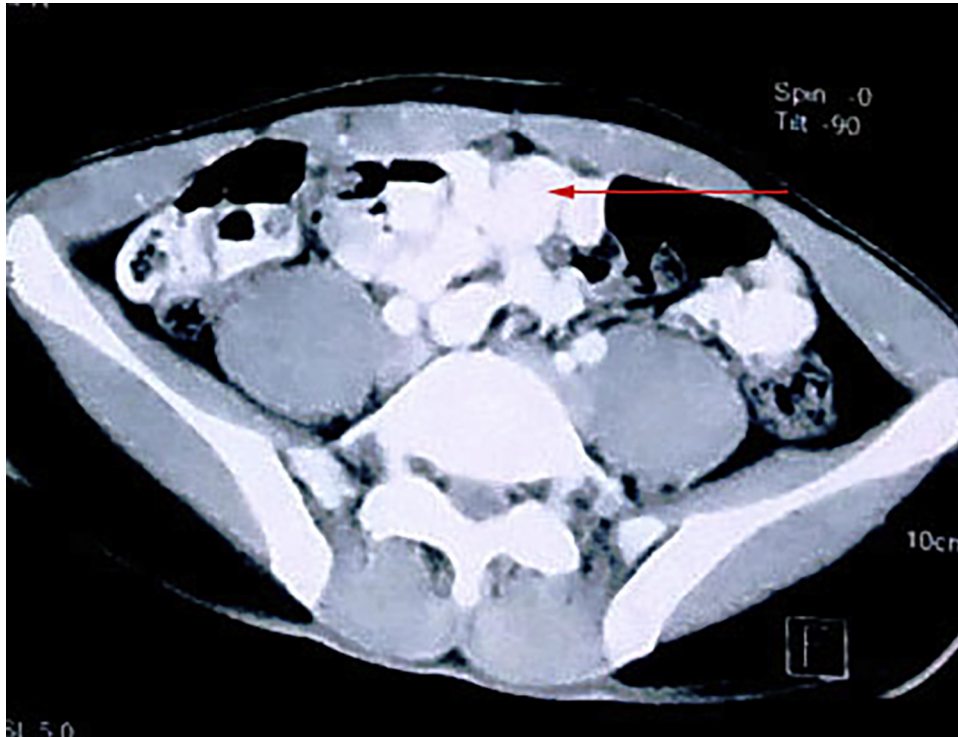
CT scan reveal the presences of urachal cyst at the anterior abdominal wall.
